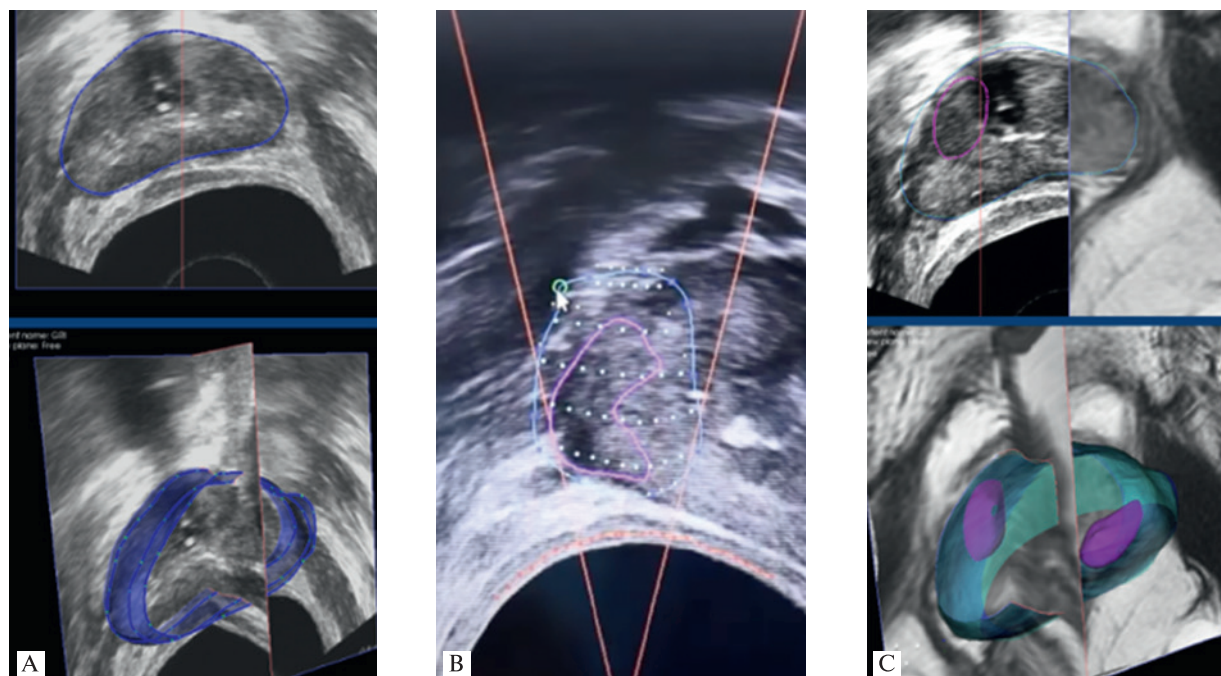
Stages of the planning of the areas of ultrasound ablation
